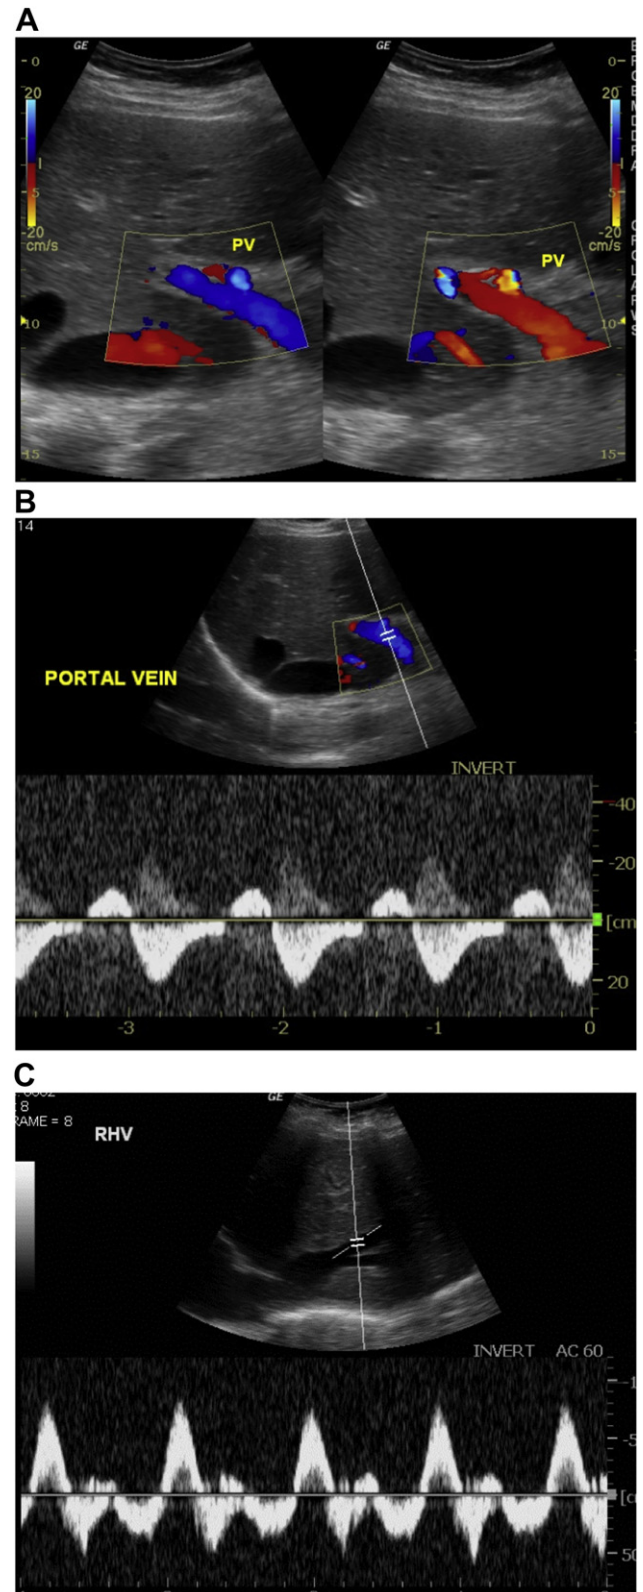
(A) Bidirectional flow is seen in the portal vein (PV) on color Doppler. (B) Pulsatile flow is seen in the portal vein on pulse-wave Doppler imaging. (C) In tricuspid regurgitation, prominent a and v waves are observed in the hepatic veins. RHV = right hepatic vein.
